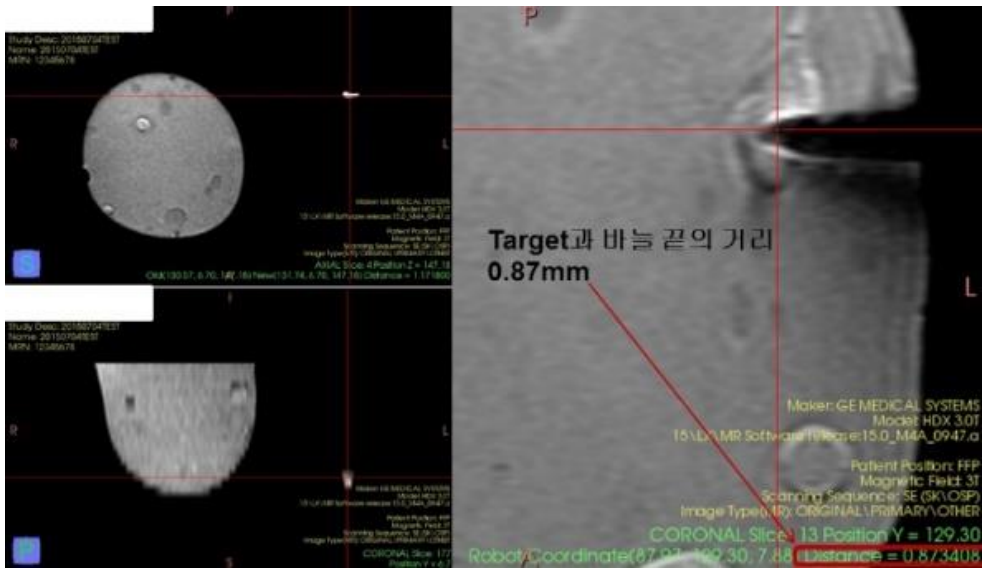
Developed MRI viewer software
